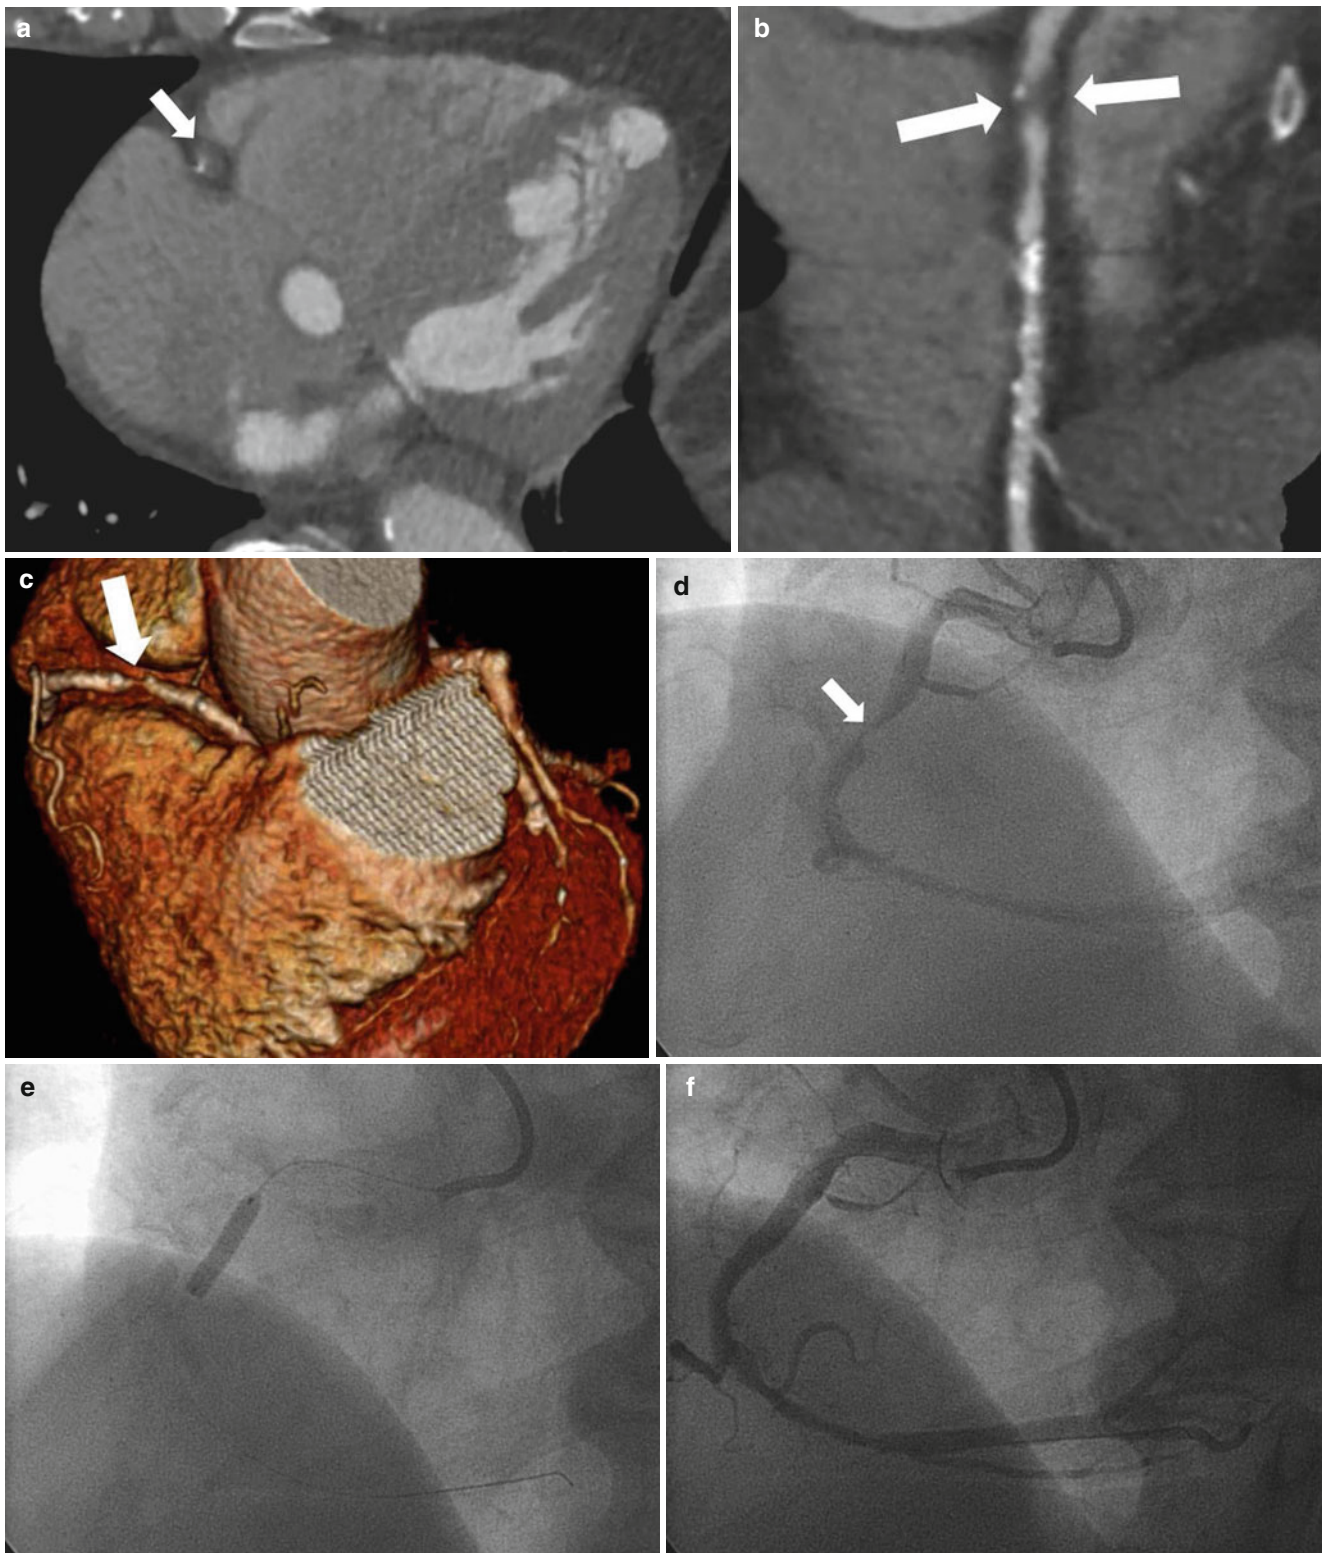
Severe degree of atherosclerotic stenosis in mRCA on CTA with one-vessel disease and Type A lesion. (a) Axial image of the right coronary artery (RCA) on coronary CTA shows severe degree of luminal narrowing with soft plaque in mRCA (arrow, one-vessel disease), and this view well demonstrates the degree of stenosis of mRCA with X-sectional plane. (b, c) Curved MPR (b) image and 3D volume-rendered (VR) (c) image of RCA on coronary CTA shows concentric soft
